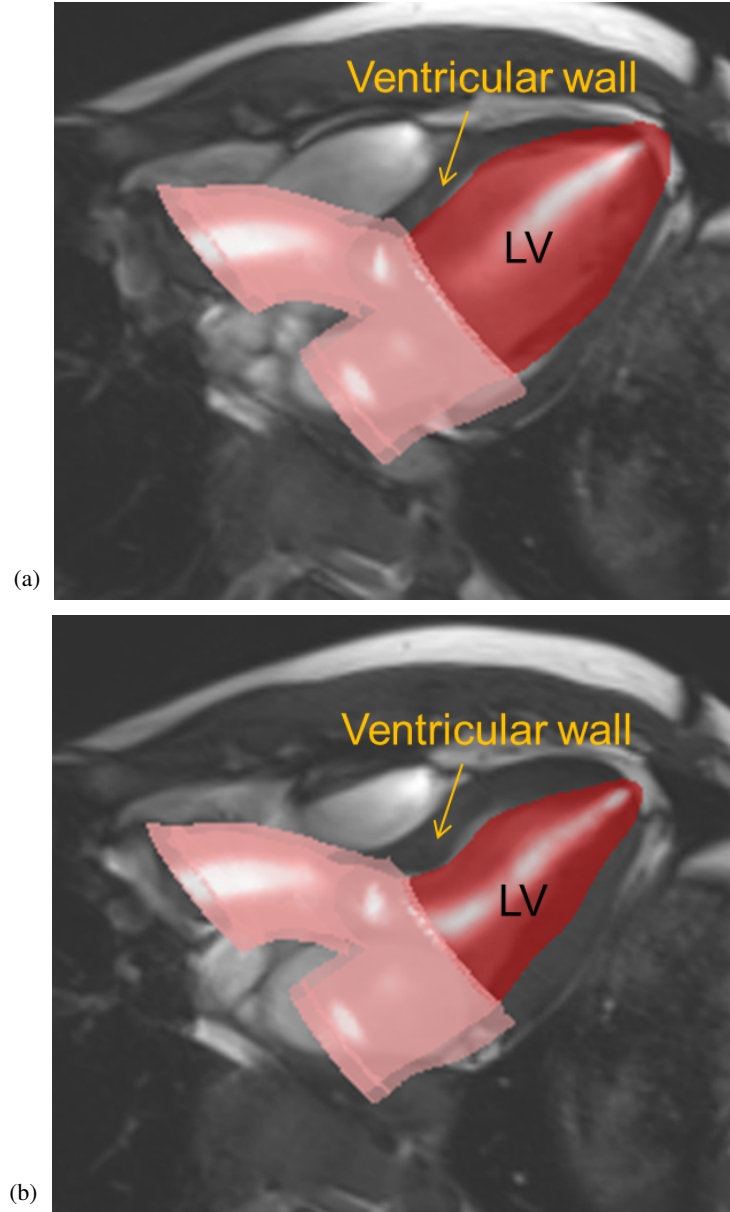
The deformed LV geometry at end of diastole (a) and end of systole (b) superimposed with cine MR images.
